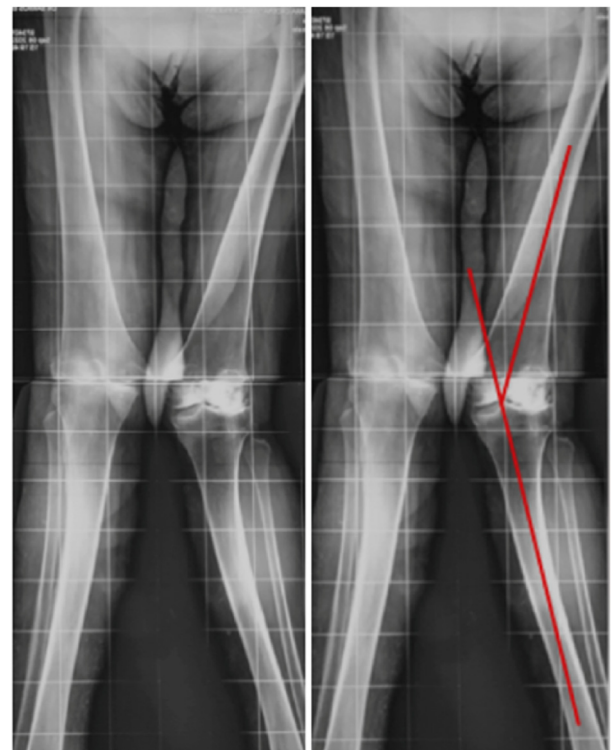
Anteroposterior (AP) radiograph of both knees and lateral radiograph of the left knee. The images reveal advanced Grade IV osteoarthritis in the left knee, characterized by significant valgus deformity, joint space obliteration, multiple osteophytes, and severe patellofemoral degeneration. These radiographic findings confirm the extensive structural damage and serve as critical preoperative references for planning the arthroplasty procedure.
